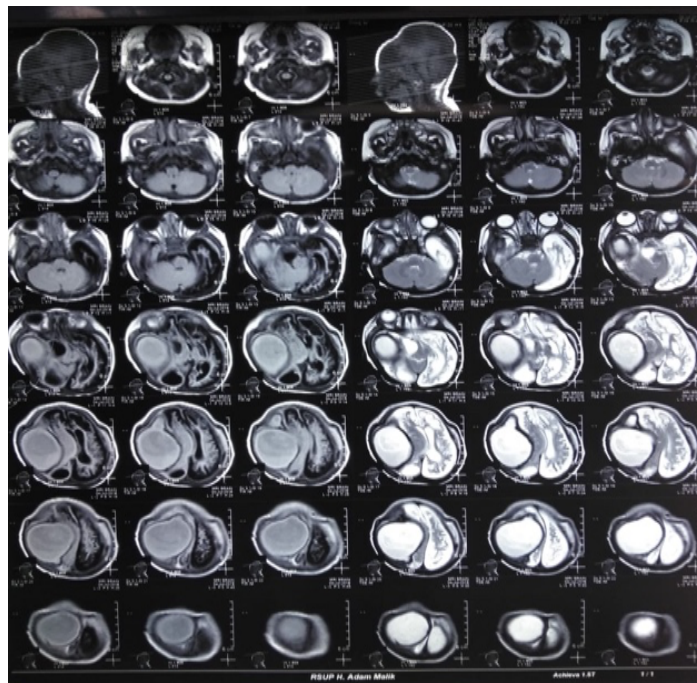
X-ray head CT scan
